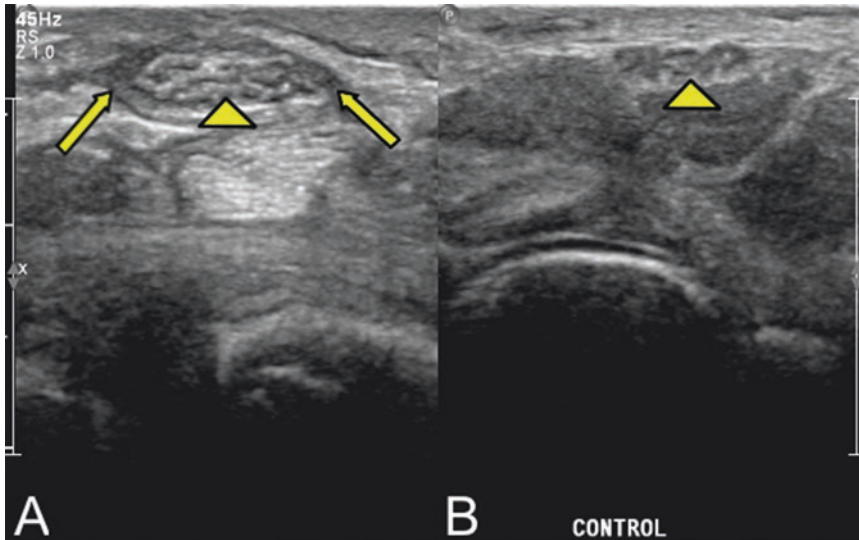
Axial ultrasound image—postoperative patient with recurrent CTS symptoms. Note the relative enlargement of the nerve (*arrowhead*) and the surrounding scar
